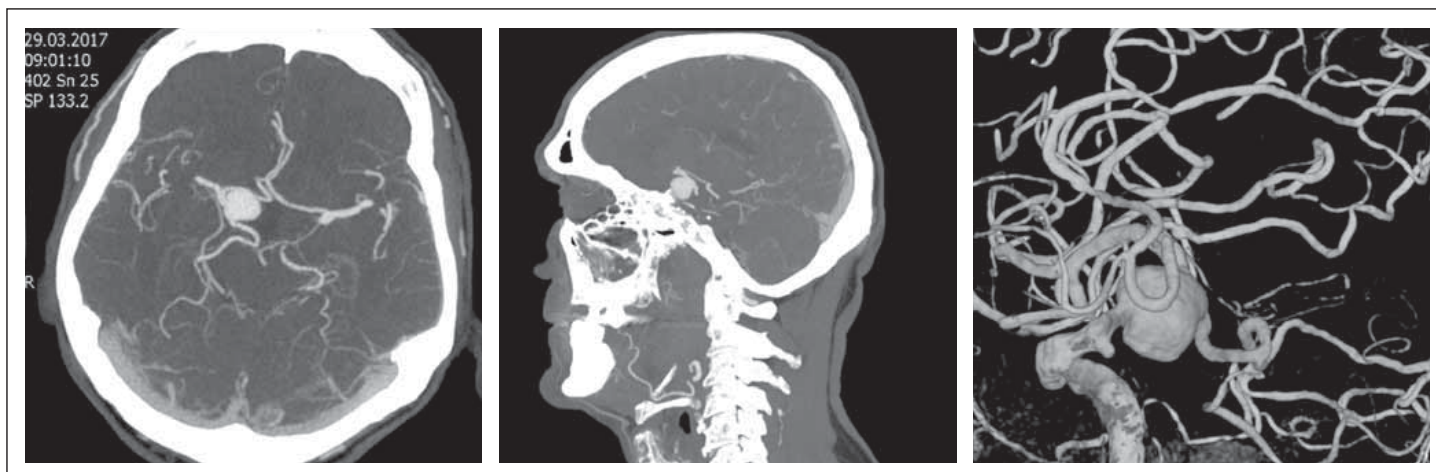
Preoperative CTA and DSA. Complex ventral carotid wall aneurysm (11 × 15 × 14 mm) on the right 2 mm distal to the origin of the ophthalmic artery and involving the posterior communicating segment of the internal carotid artery with a fetal-type posterior communicating artery arising from the aneurysm sac. The anterior choroidal artery was distal to the aneurysm.
